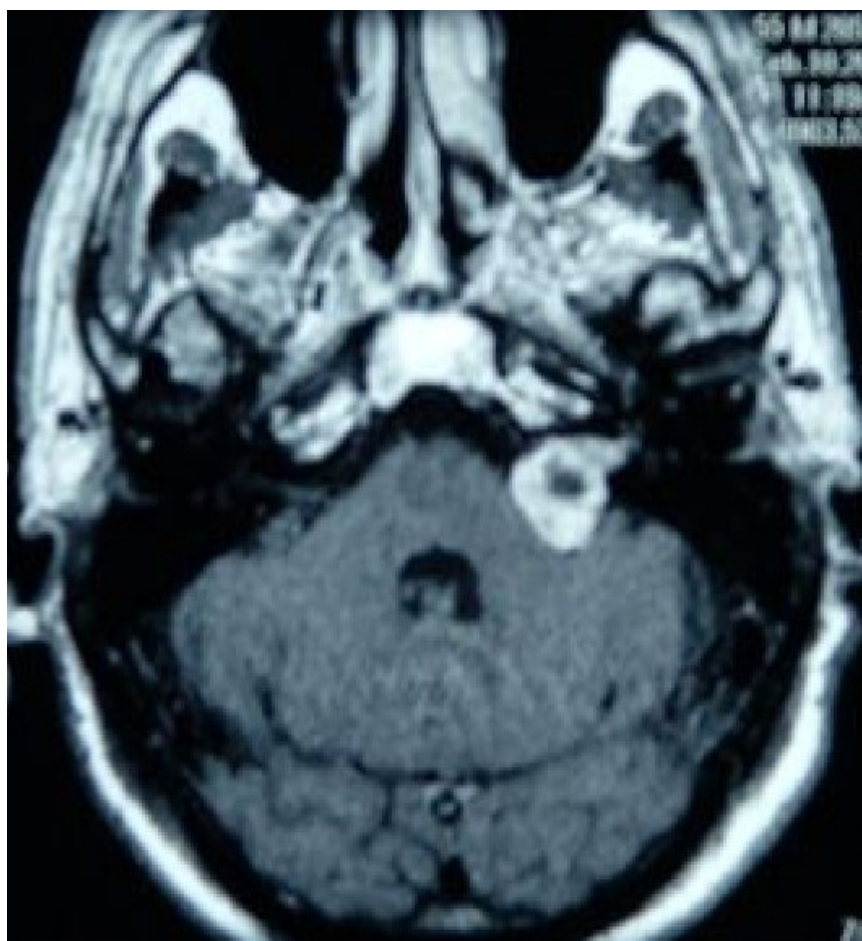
Contrast-enhanced MRI demonstrating a vestibular schwannoma in the internal auditory canal/cerebellopontine angle. Wikimedia Commons, CC BY 2.0.
